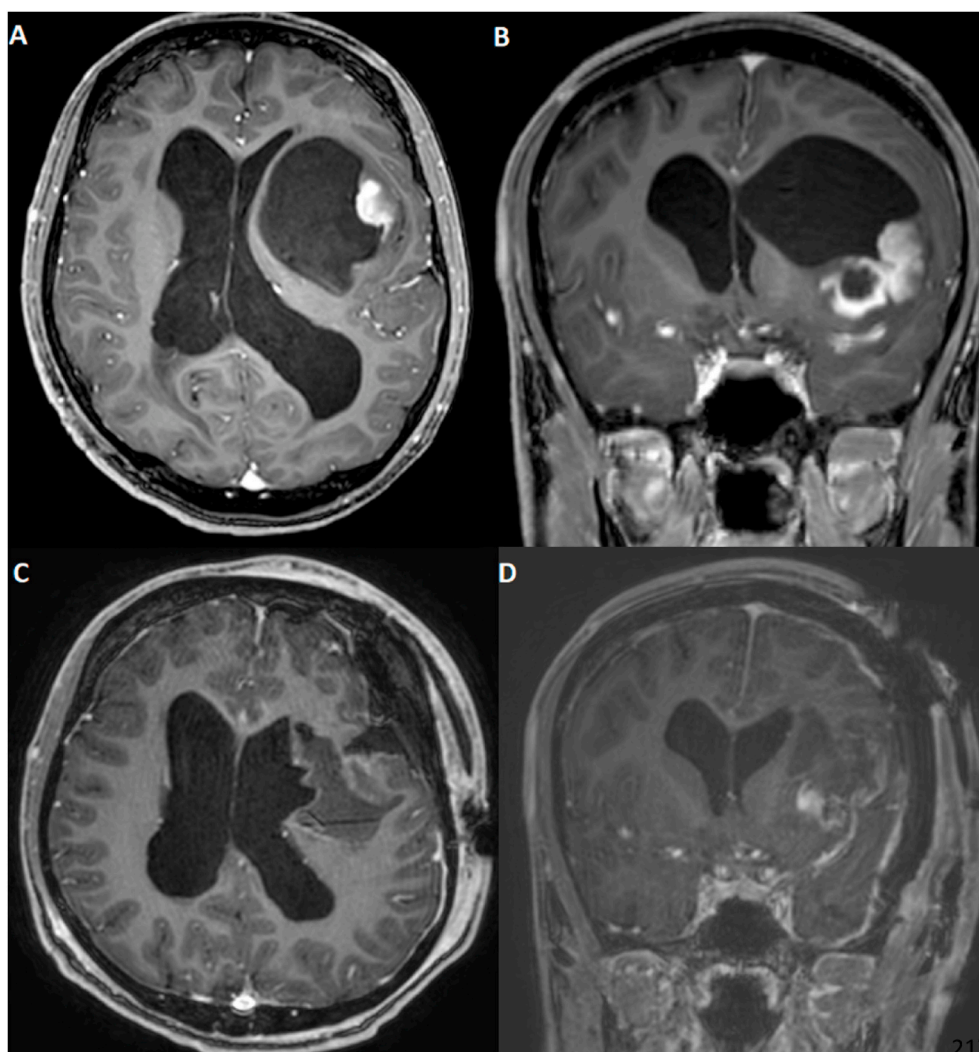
Brain MRI with contrast; A) Axial preoperative, B) Coronal preoperative, C) Axial postoperative, D) Coronal postoperative views.
